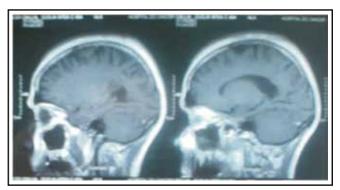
2010: MRI without cancer, just gliosis
